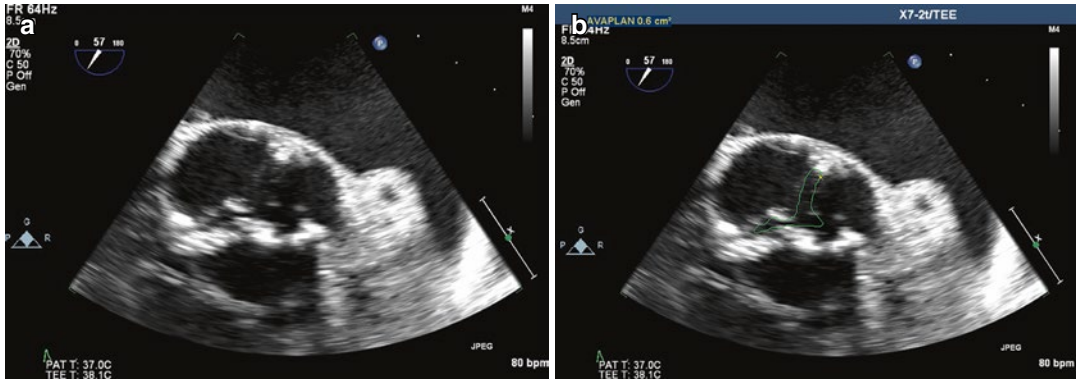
Parasternal short axis of a severely stenotic aortic valve with mid-systolic frame without (a), and with planimetry of the estimated orifice area (b). Note that
